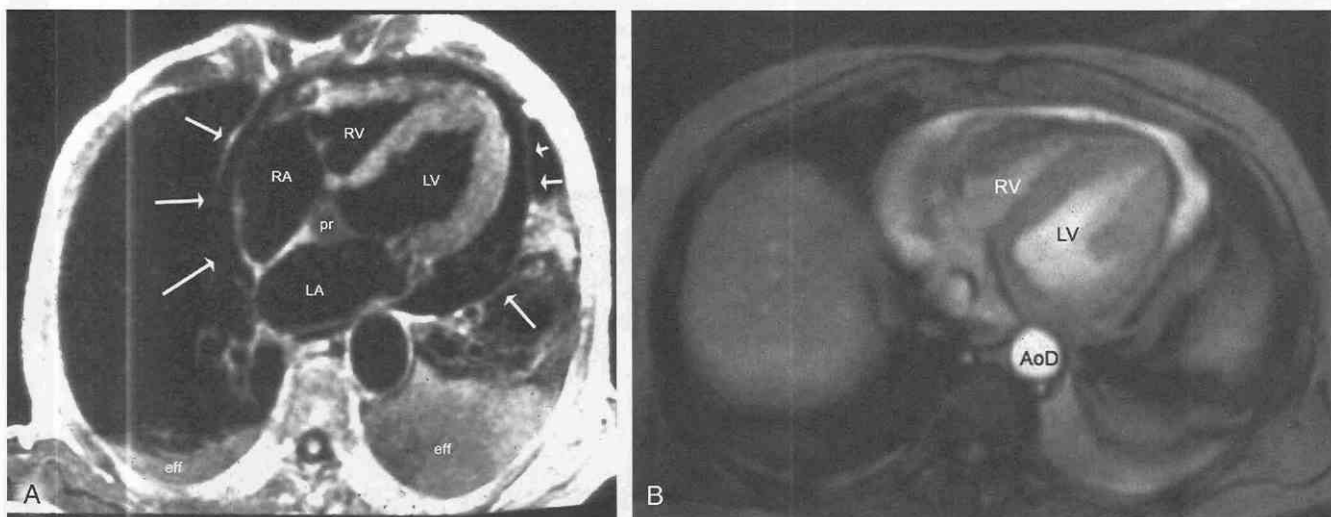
MR image obtained from two patients with simple pericardial effusions. *A*, The patient is a 64-year-old man with progressive shortness of breath. In this oblique axial section through the posterior right aortic sinus of Valsalva (pr), the parietal pericardium (arrows) is separated from the epicardial surfaces of the heart. The left ventricle (LV), right ventricle (RV), left atrium (LA), and right atrium (RA) are labeled. Note the bilateral pericardial effusions (eff) as well. *B*, In this axial gradient-echo acquisition (in another patient), the high-signal-intensity serous pericardial fluid surrounds the heart. AoD, descending aorta; LV, left ventricle; RV, right ventricle.
